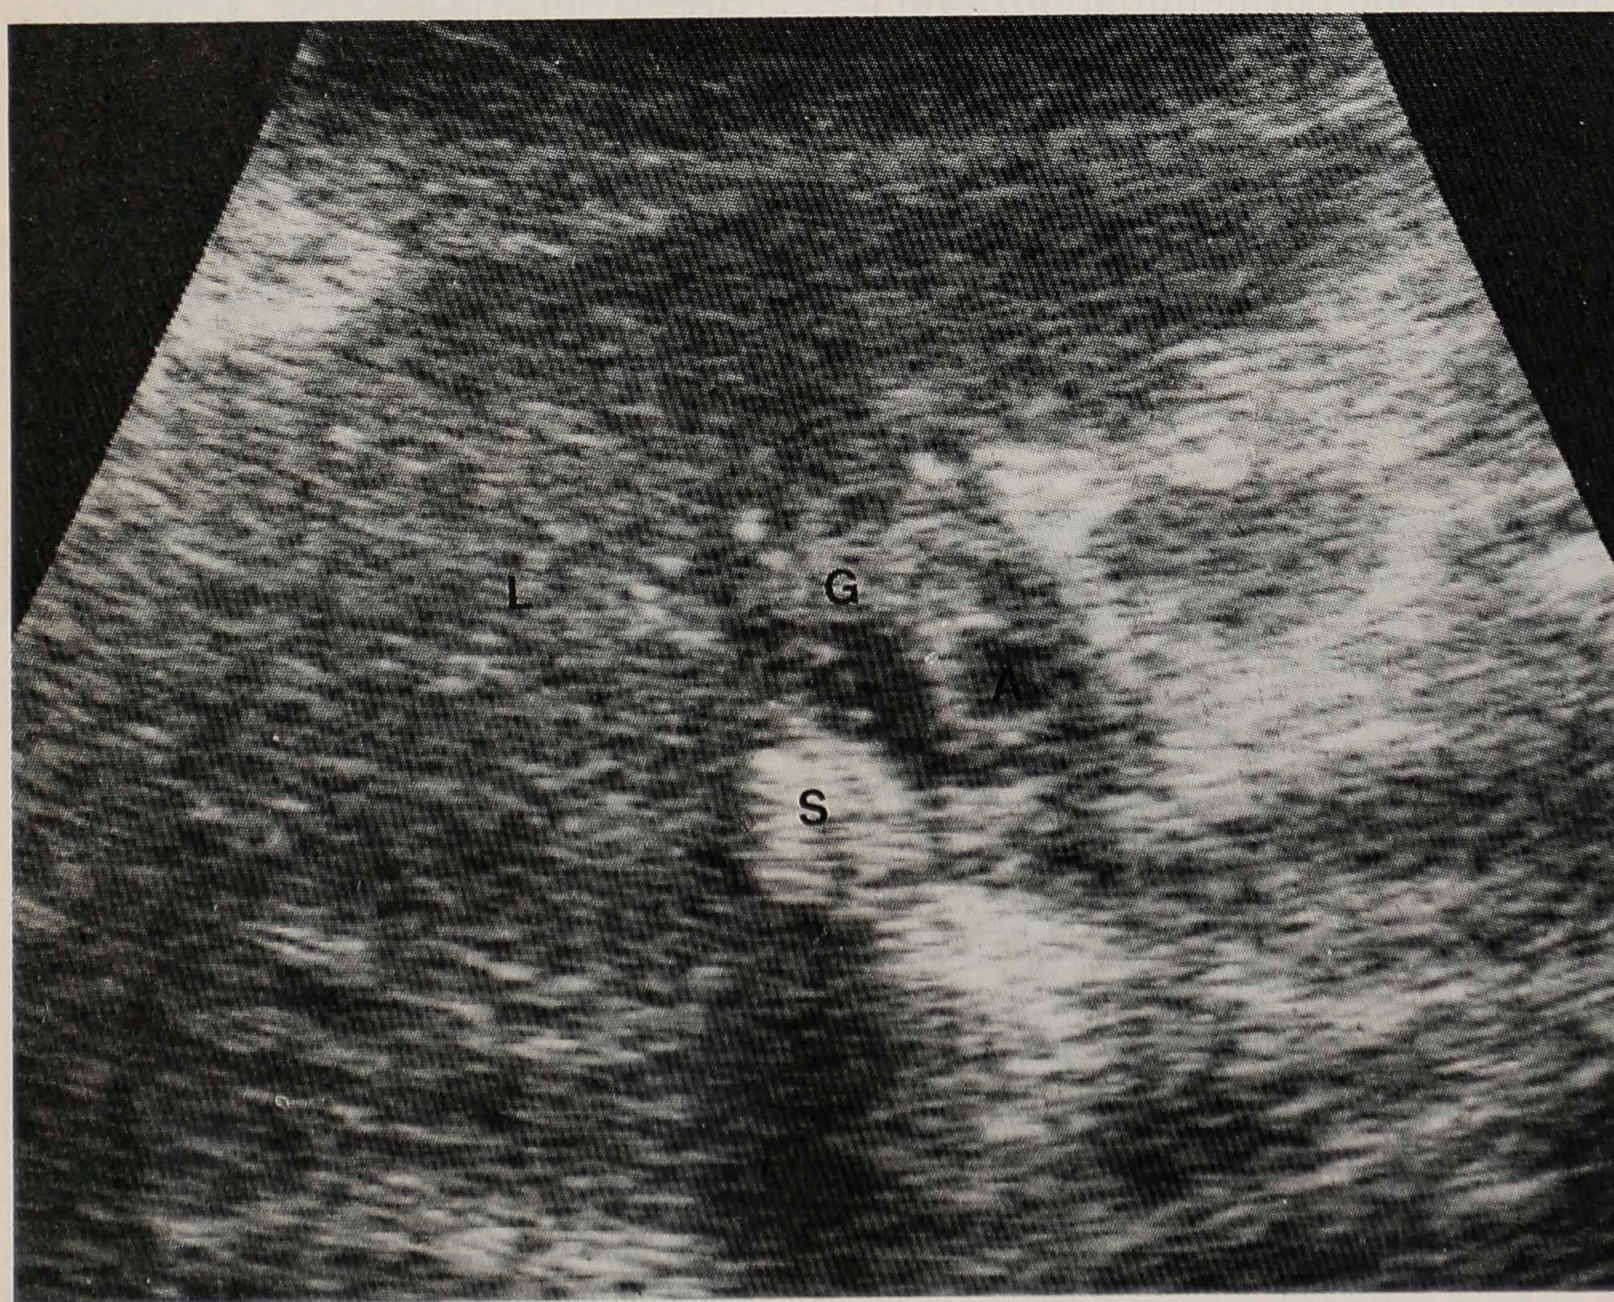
Colour Doppler ultrasonography. Oblique scan through right upper quadrant shows liver (L) and gallbladder (G). Gallbladder contains stone (S), and aneurysm (A) is visible in gallbladder wall.
